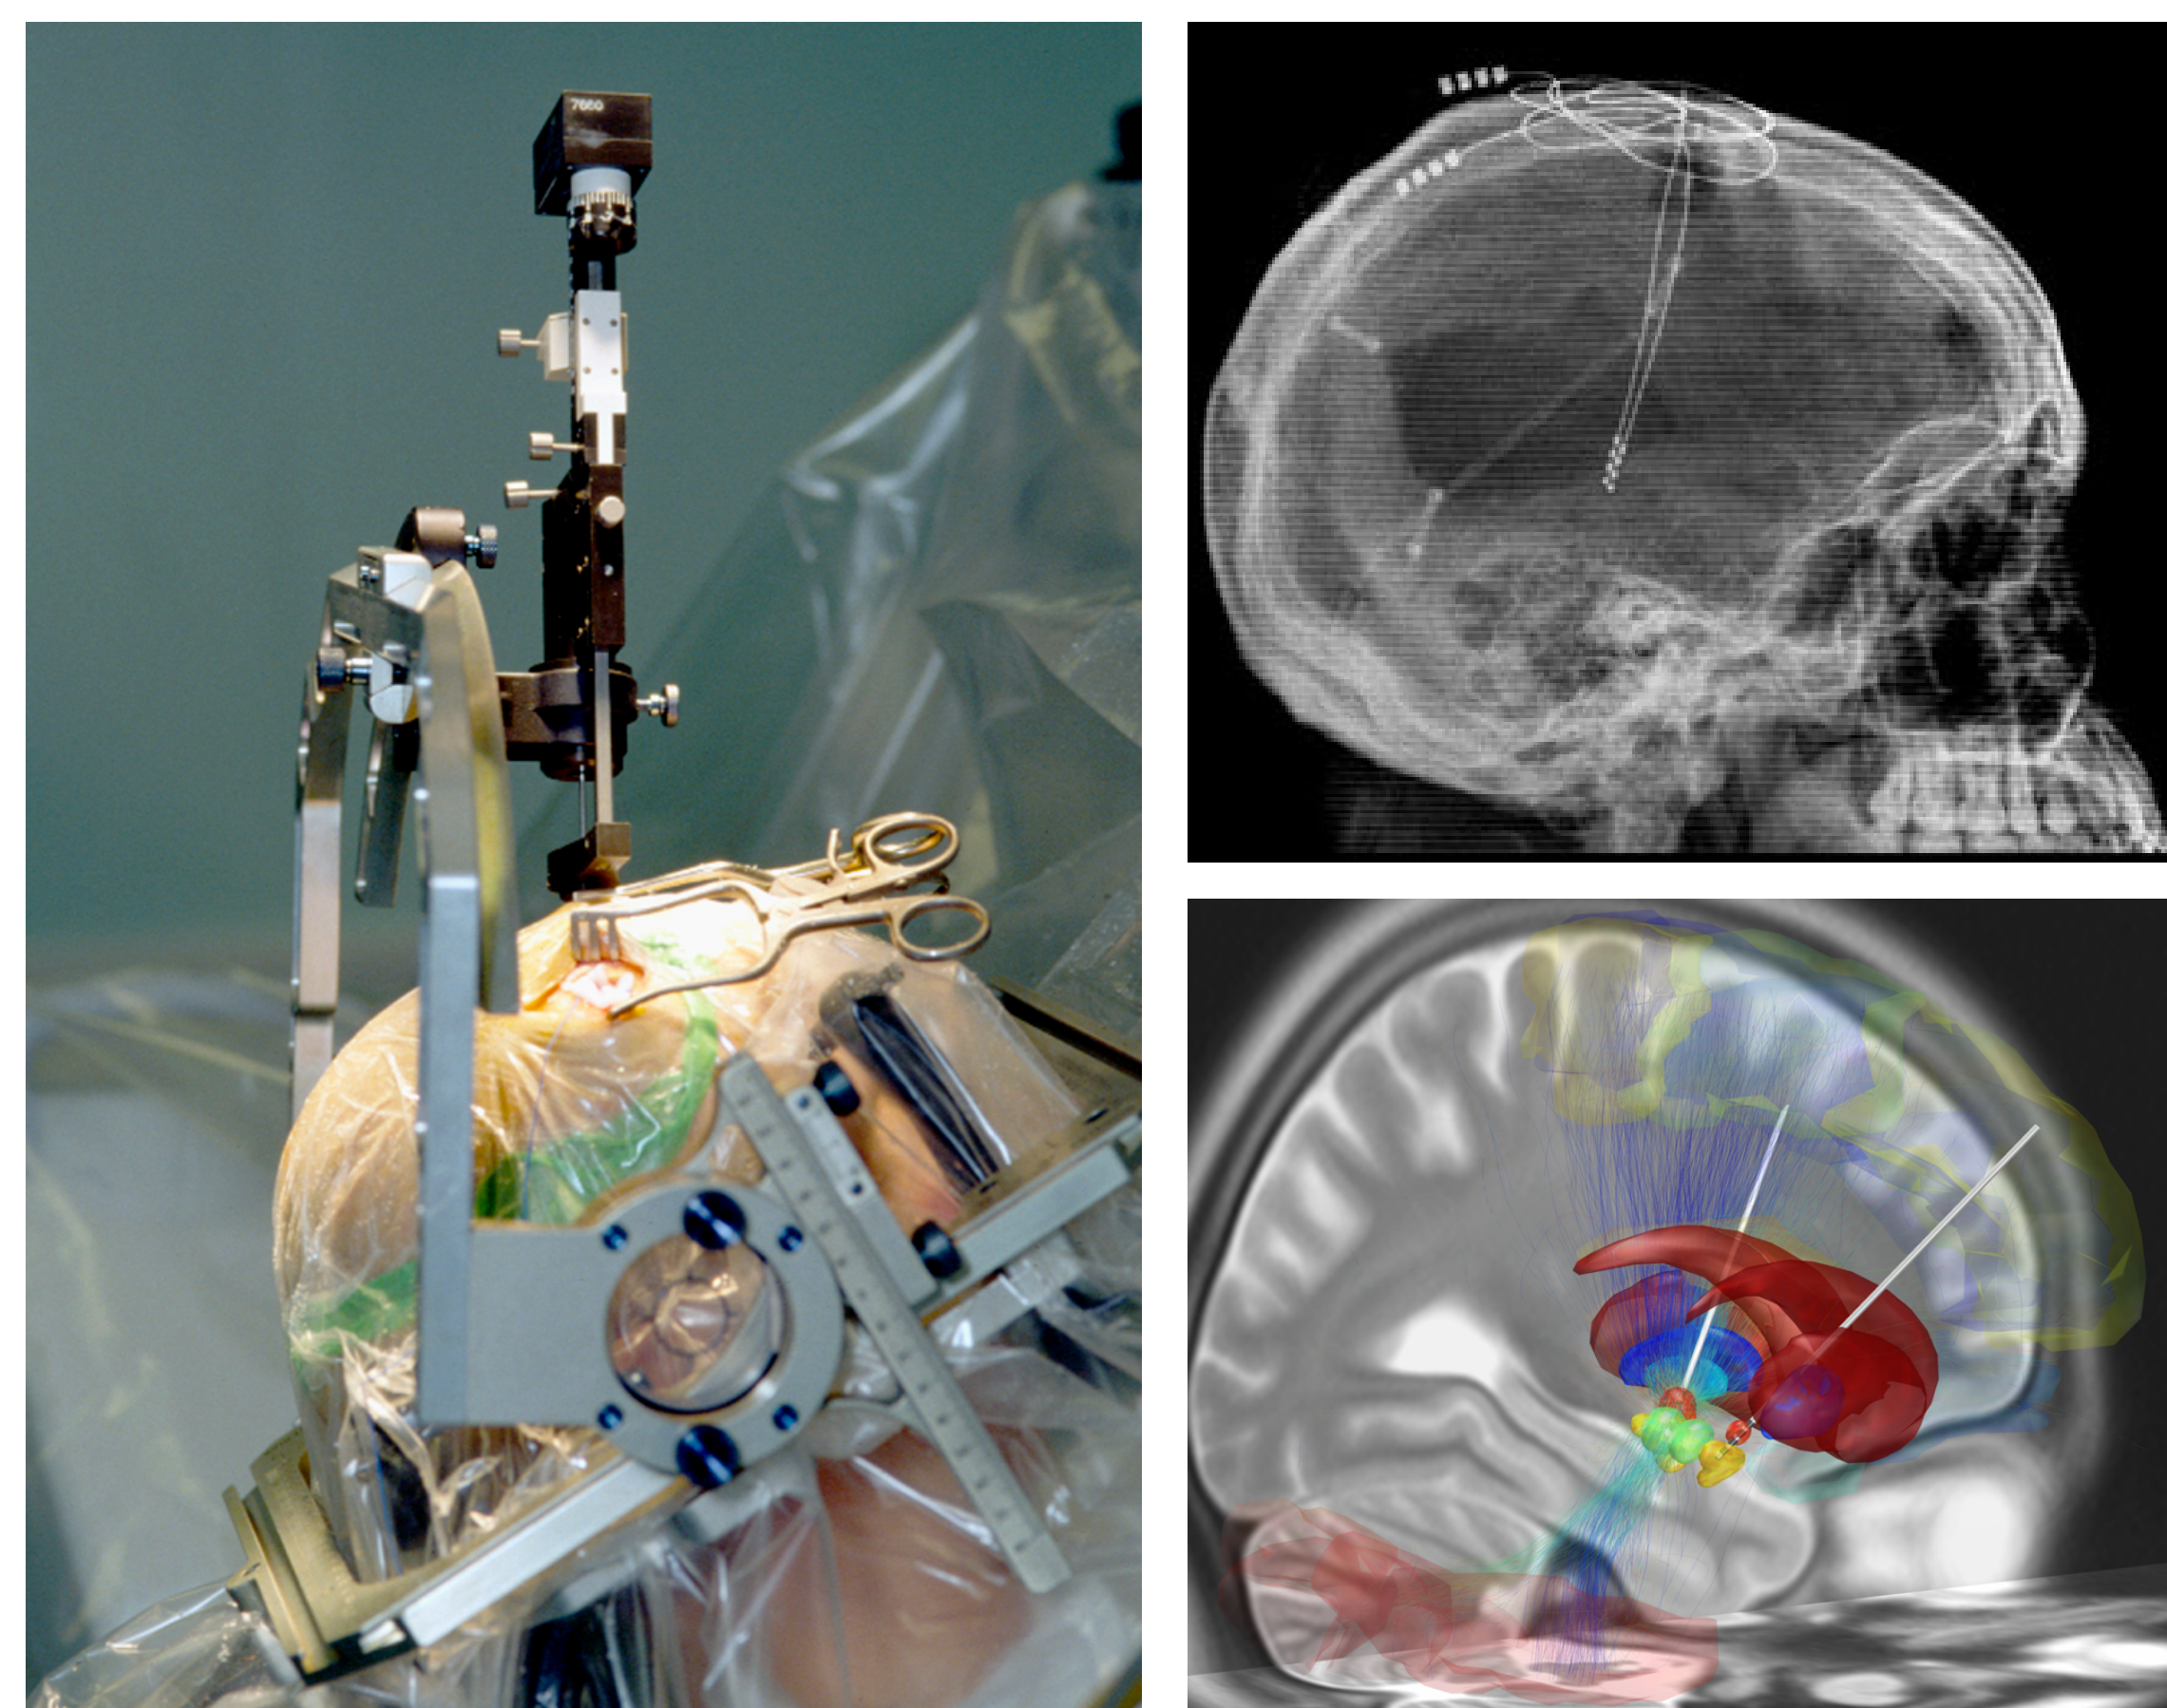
a) Surgical procedure using stereotactic system to implant DBS electrodes. b) CT scan of the implanted DBS electrodes in STN for a patient with Parkinson's disease. c) 3D reconstruction of DBS electrode implantation in STN.
